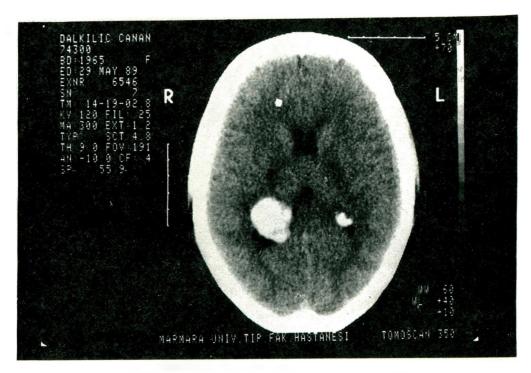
The CT scanner of Case 2 also revealed a hyperdense mass.
